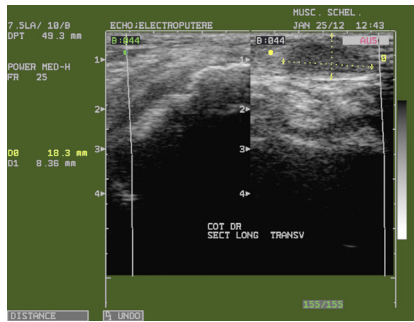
Ultrasound image of a RN localized by the right olecrani.
